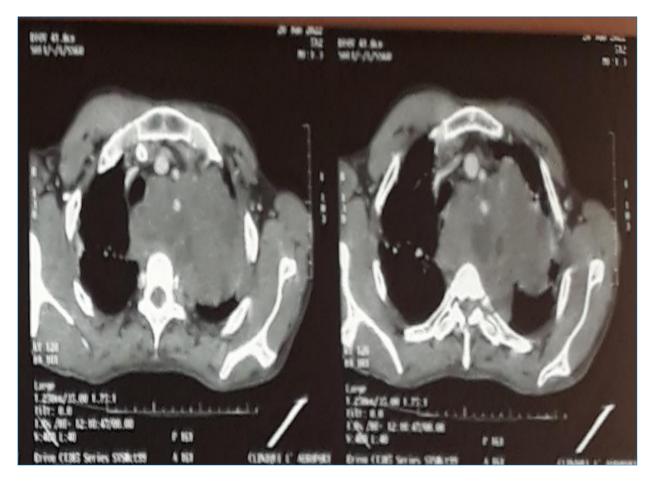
Axial thoracic CT scan showing the voluminous infiltrating mediastinal tumor
